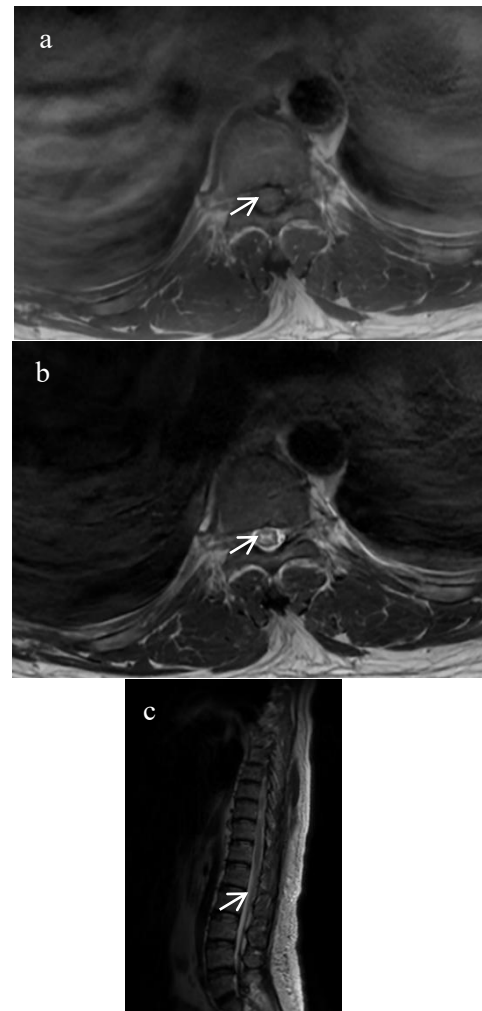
(a) Findings on contrast-enhanced thoracic MRI: axial T1-weighted sequence demonstrates intramedullary hypointensity. (b) Findings on contrast-enhanced thoracic MRI: T2-weighted sequence reveals intramedullary hyperintensity, producing the characteristic "owl's eye appearance". (c) Findings on contrast-enhanced thoracic MRI: Ssagital T1-weighted sequence demonstrates intramedullary hypointensity (white arrow)
